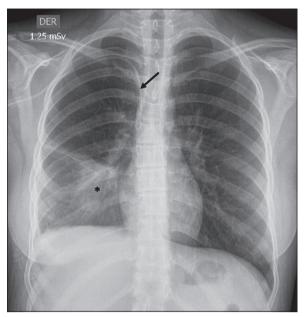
Chest radiograph. Evidence a triangle opacity (asterisk) in right lower lobe posterior segment. Central venous catheter is observed (arrow).
